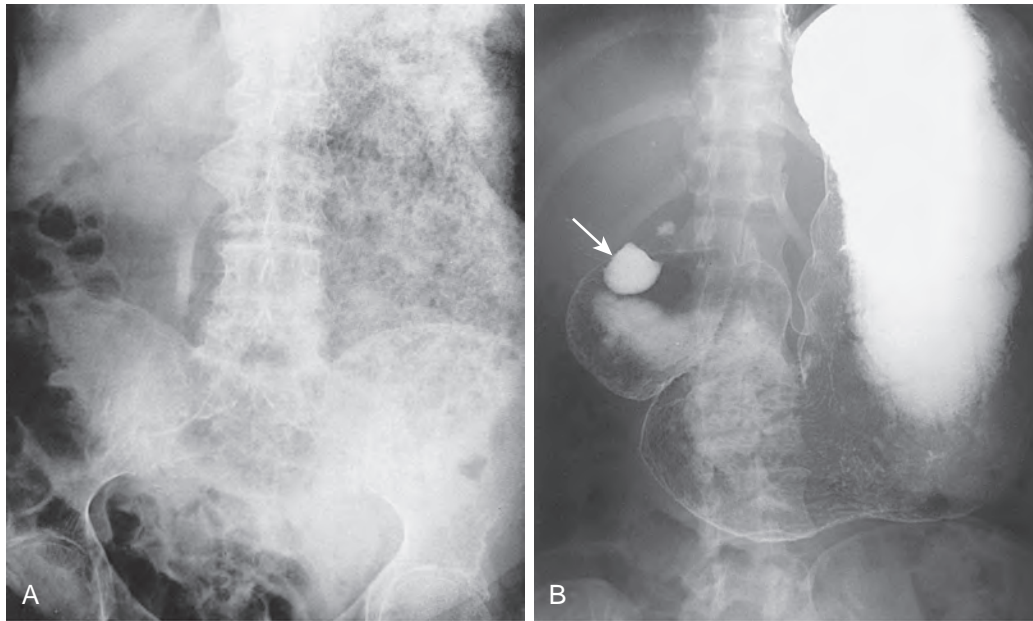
Gastric outlet obstruction caused by pyloric channel ulcers. A. Abdominal radiograph shows a markedly dilated stomach with retained food and debris caused by gastric outlet obstruction. After the stomach was decompressed, endoscopy revealed a pyloric channel ulcer causing the obstruction. B. In another patient, an overhead radiograph from a barium study shows a dilated stomach with retained fluid diluting the barium and no emptying into the duodenum. A large pyloric channel ulcer (arrow) is also seen.
